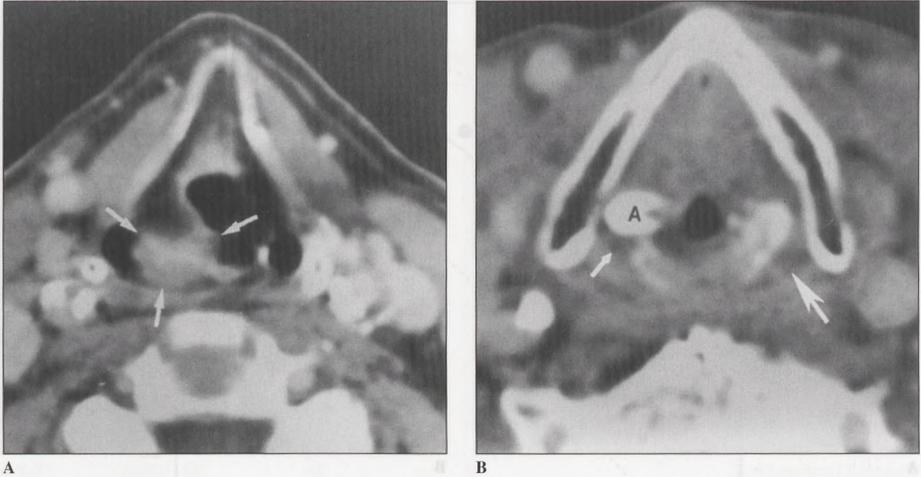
Sequential CT images of a 4.6-cm³ pyriform sinus tumor which was successfully controlled with definitive RT. (A) There is an exophytic lesion (arrows) involving the medial wall of the right mid-pyriform sinus. (B) At the level of the pyriform sinus apex (small arrow), no tumor is seen. The appearance is similar to the opposite apex (large arrow). There is associated sclerosis of the right arytenoid cartilage (A).
